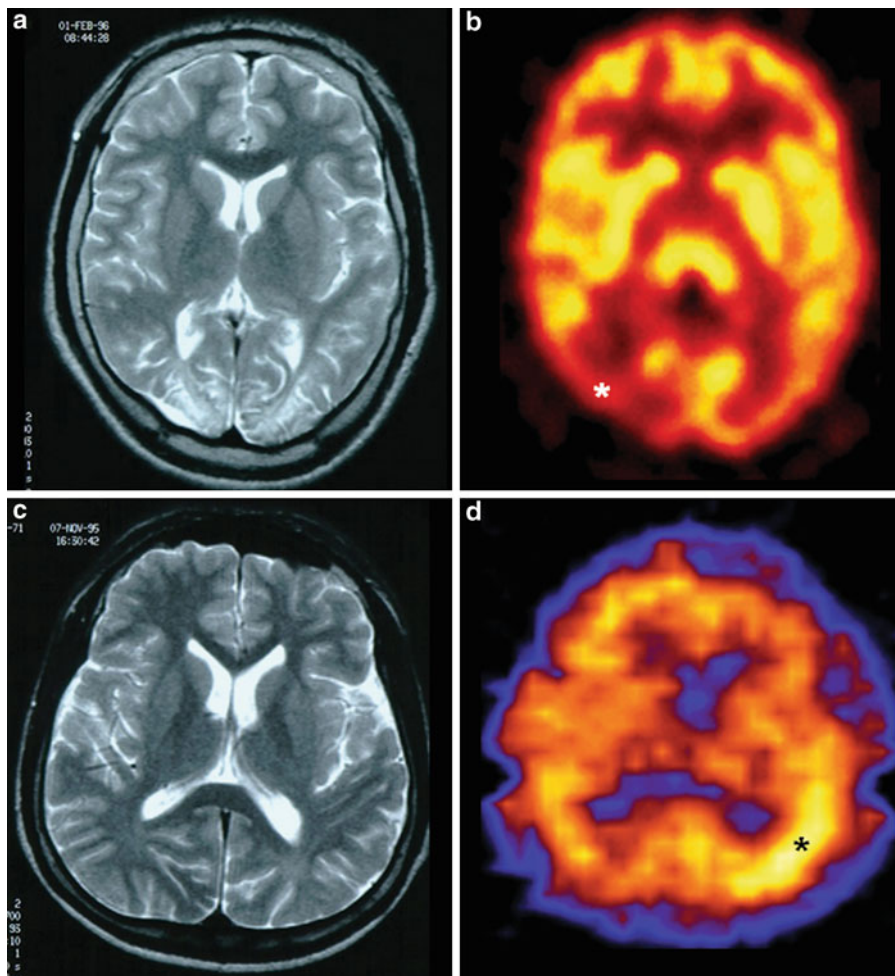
Cases of occipital lobe epilepsy. Selected T2-weighted axial MR image of the brain (a) was normal, but metabolism with ^{18}F -FDG was decreased in the right occipital lobe epilepsy (*) on the axial image of the head (b).
